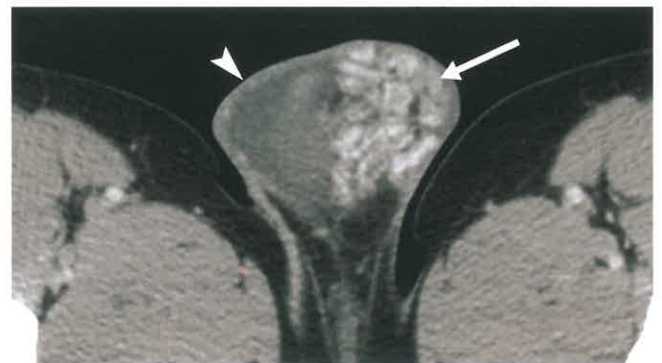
Varicocele and Hydrocele. Axial postcontrast CT through the scrotum reveals a large hydrocele (arrowhead) on the right and a very large enhancing varicocele (arrow) on the left.
